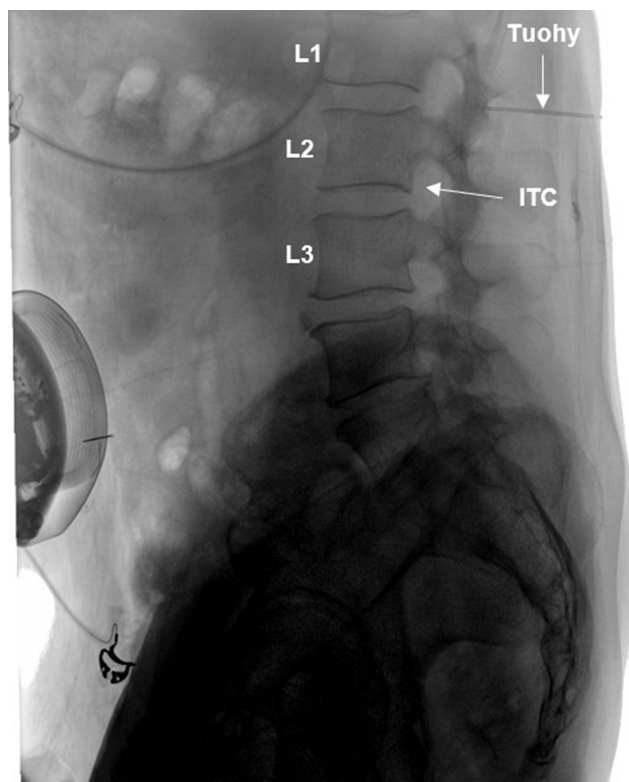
Lateral view of portable X-ray machine demonstrated the Tuohy needle entering the epidural space at L1–L2 level above ITC. The locations of the Tuohy needle and ITC are indicated with arrows respectively.
